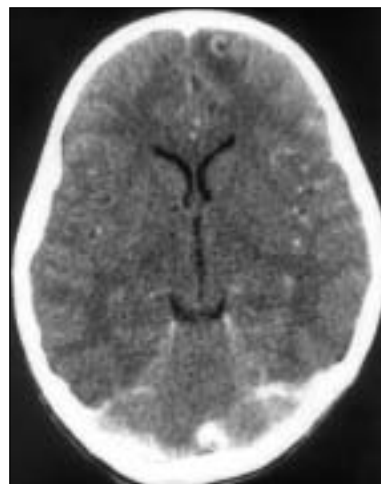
Post-contrast axial CT scan of the brain showing a ring-enhancing lesion in the left medial frontal lobe suggestive of solitary cysticercus granuloma
